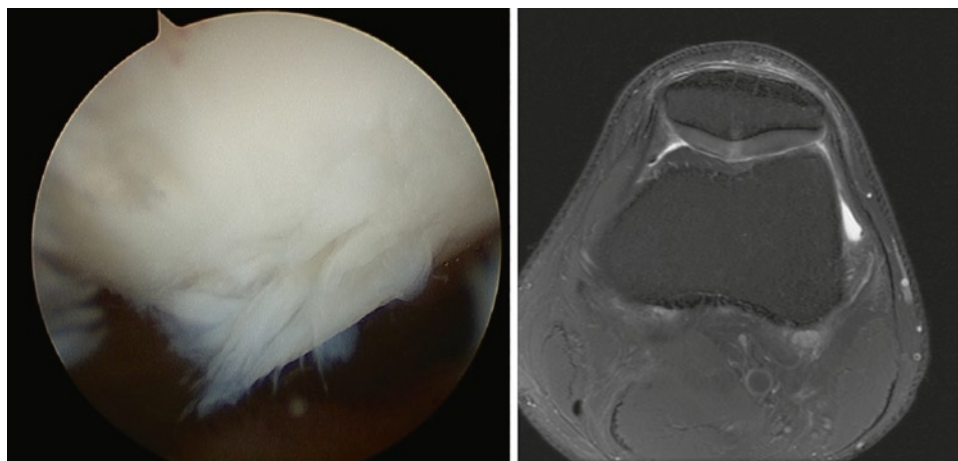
Grade 2 Outerbridge defect of the patella apex. *Left:* Arthroscopic view. *Right:* Corresponding axial T2-weighted MRI sequence
